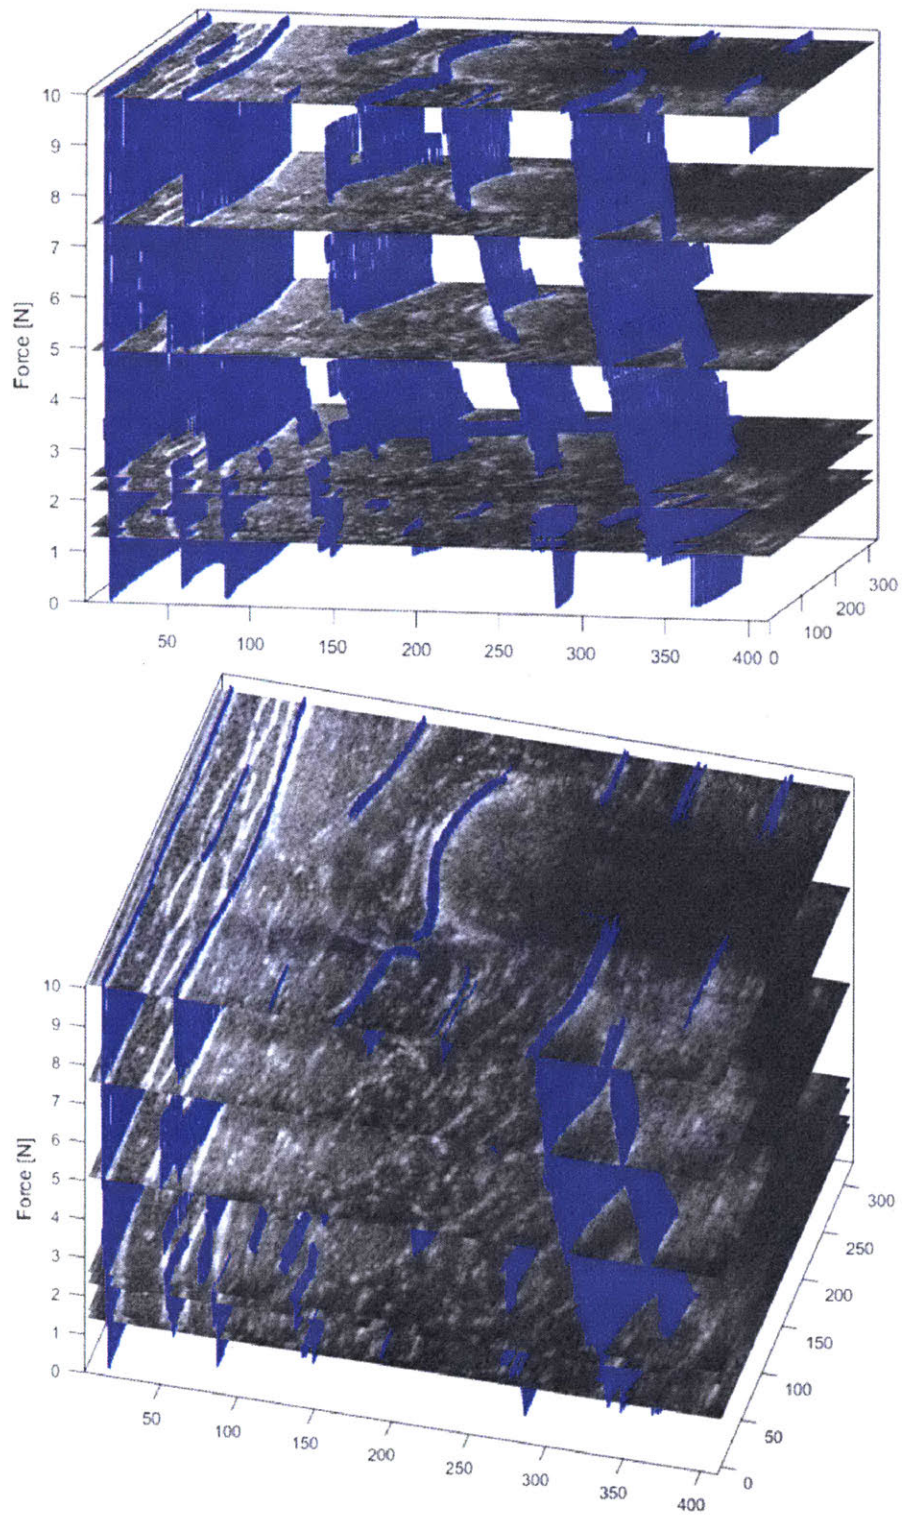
Automated propagation of tissue interfaces in ultrasound images
